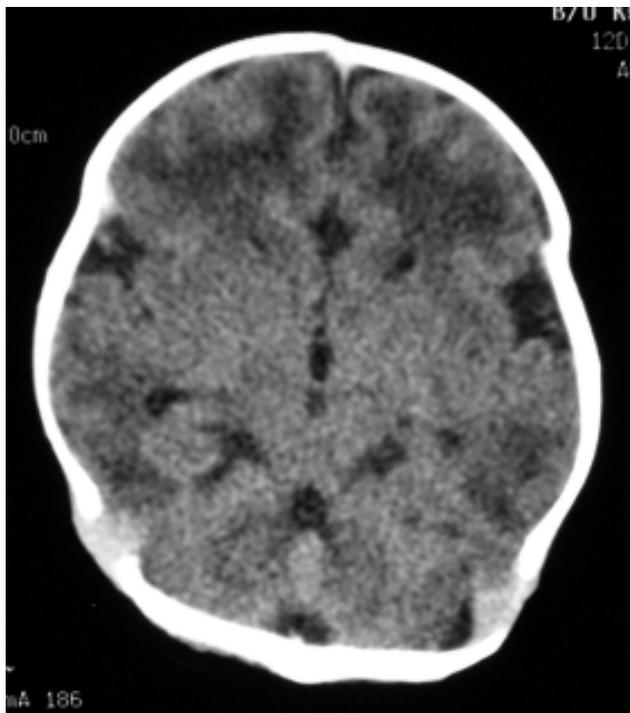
The white matter appeared hypodense on the pre-contrast CT brain study. The ventricular system and sulcal spaces are slightly capacious.
